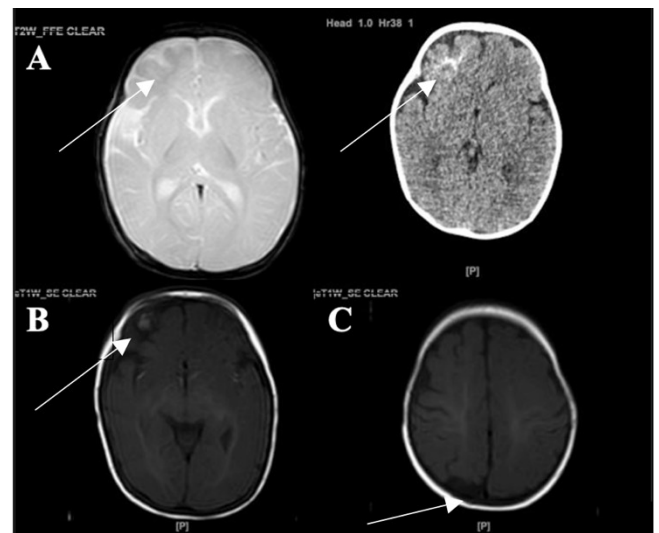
(A) Non-contrast head MRI correlates with a non-contrast head CT scan, showing calcification and atrophy of the right frontal lobe and widening of the vein of Galen. (B) A non-contrast head MRI showed a prominent vascular structure in the right frontal lobe. (C) Noncontrast head MRI showing widening of the superior sagittal sinus
